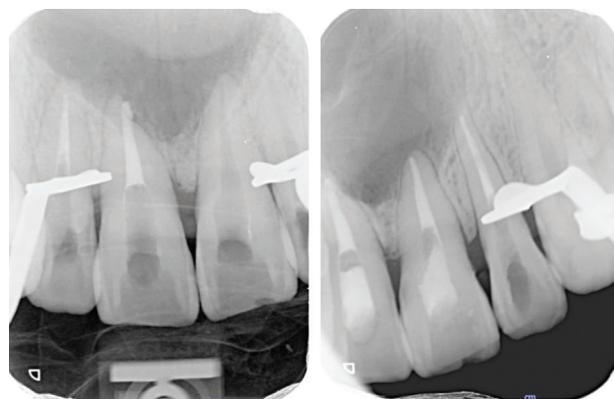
Periapical radiographs, a 2-month follow-up after total enucleation.
